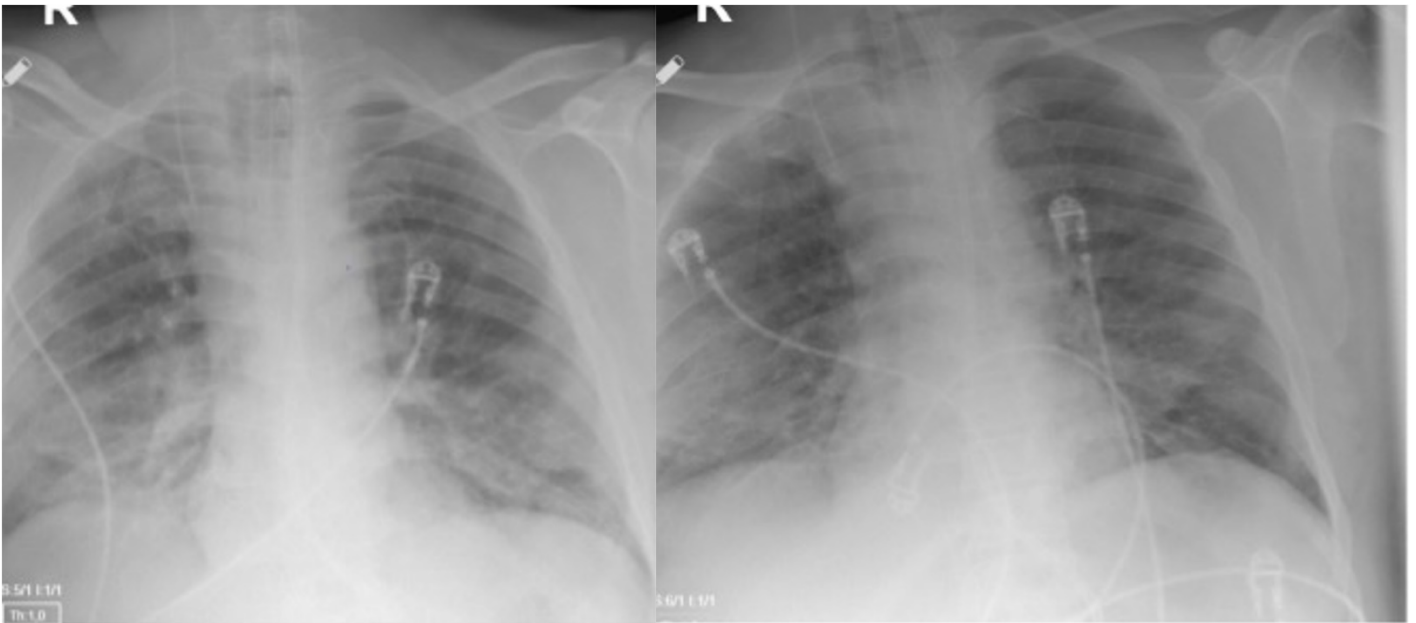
On the left side is the patient's X-Ray before bronchoscopy, and on the right side is the X-Ray after bronchoscopy. Although fibrinous plug made clinical changes on respiration, the X-ray did not show these changes
